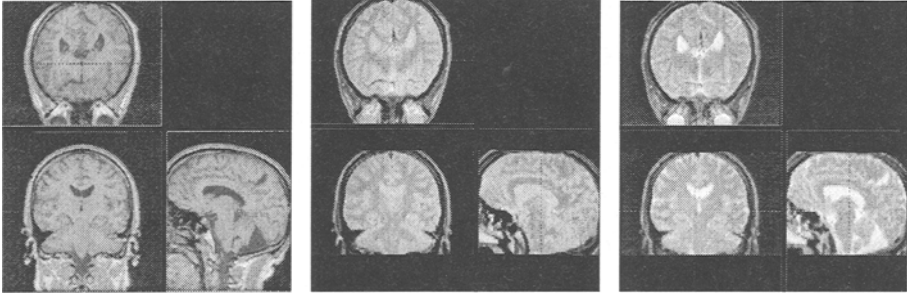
SPGR, Proton Density, and T2 Weighted Magnetic Resonance images of a brain. Notice that some anatomical structures appear with more contrast in one image than the others.
